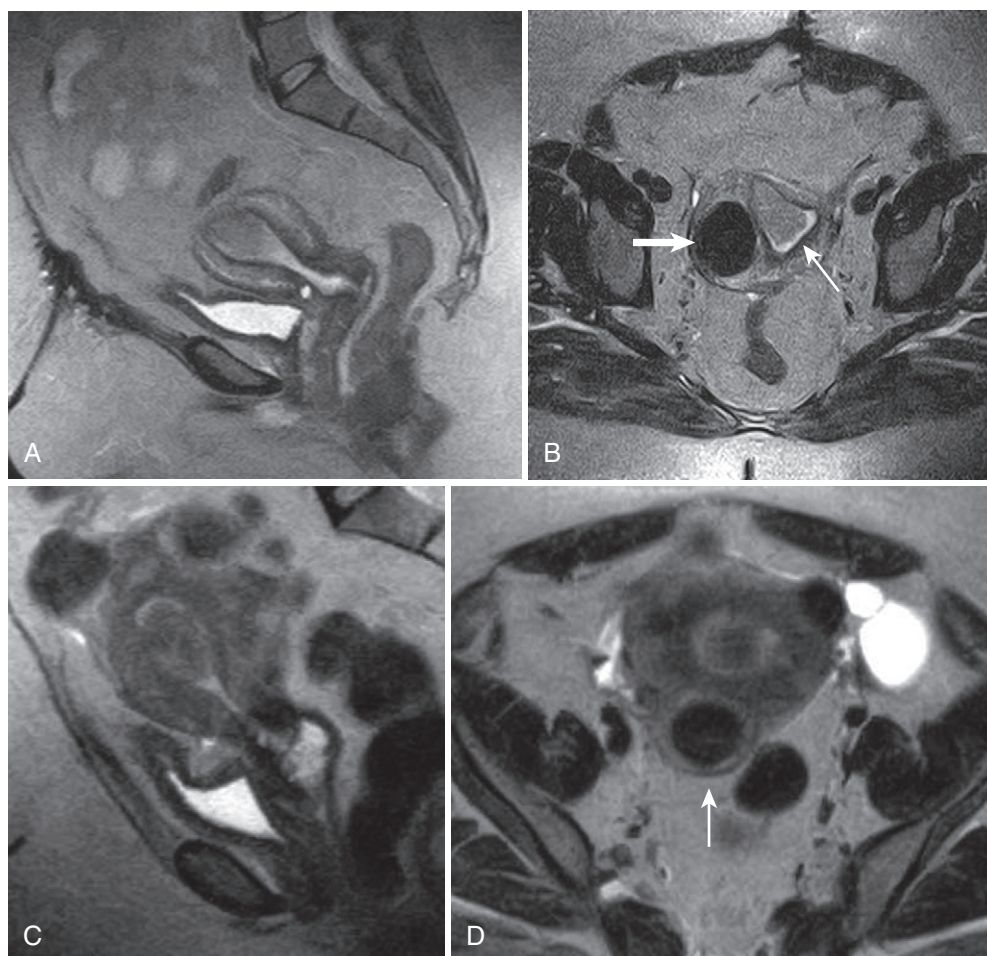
0.3-Tesla images. A, Sagittal T2-weighted image through the uterus obtained on a 0.3-Tesla system reveals an isointense endometrial mass with no deep myometrial invasion corresponding to endometrial carcinoma. B, The corresponding axial T2-weighted image shows normal endometrium (*thin arrow*) abutting the distal aspect of the mass and an intramural fibroid (*thick arrow*). Sagittal (C) and axial (D) T2-weighted images through the uterus obtained on a 0.3-Tesla system in a different patient show a tubular mildly hyperintense lesion with a hypointense core within the endometrial cavity found to be an endometrial polyp. Also note the partially subserosal fibroid arising from the posterior uterine body (*arrow* in D).
